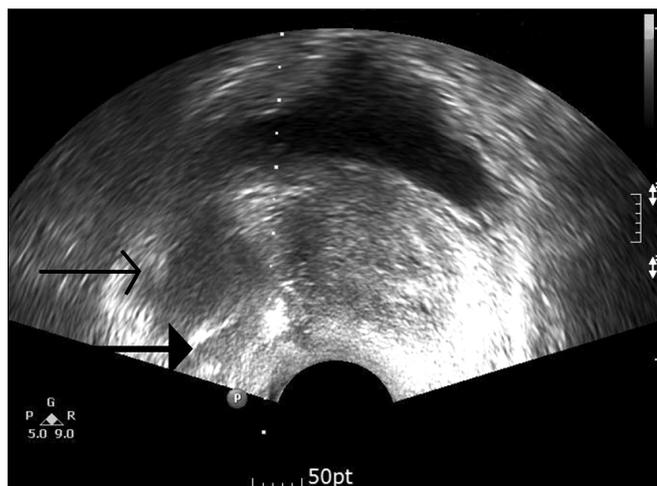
Transrectal prostate ultrasonographic image (sagittal view). The ultrasonic wheal (collection of lidocaine) is seen as a hypoechoic space (arrow head). The narrow arrow indicates the seminal vesicle.
